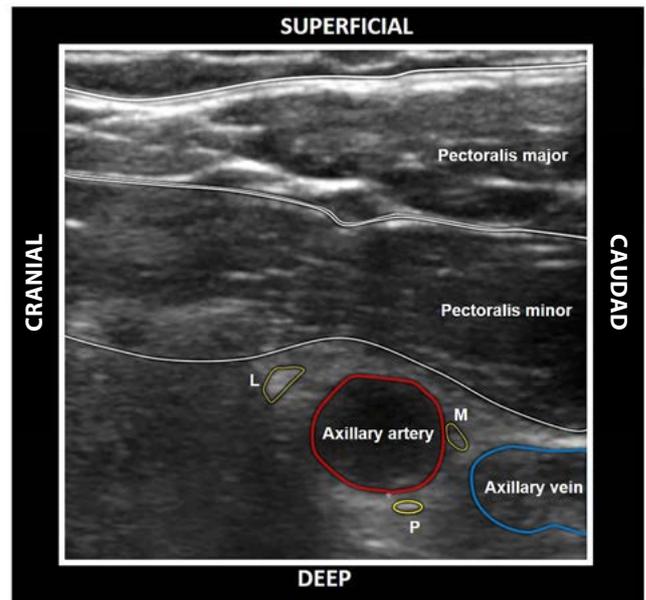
An ultrasound scan, showing the muscular and vascular structures in the infraclavicular fossa. Key: L – lateral cord, M – medial cord, P – posterior cord.
